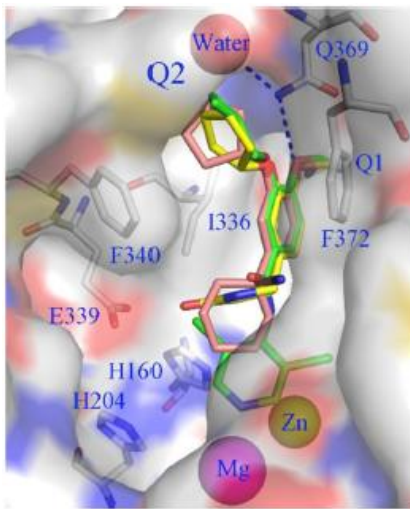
X-ray structures of PDE4 molecules (Peng et al. 2020)
